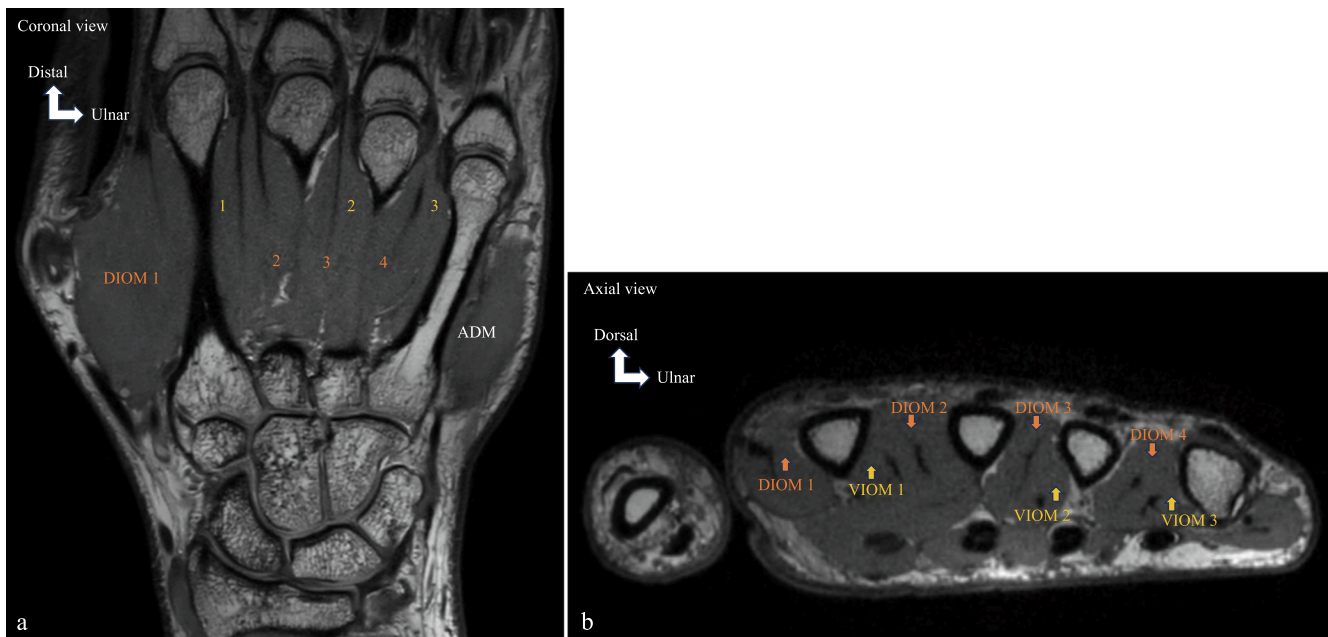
MRI showing the proximal insertions of the dorsal and palmar interosseous muscles. Coronal (a) and axial (b) proton density (PD) MRI sequences. Dorsal interosseous muscles are shown in dark red; palmar interosseous muscles in light orange. VIOM 1, First ventral interosseous muscle; VIOM 2, Second ventral interosseous muscle; VIOM 3, Third ventral interosseous muscle; DIOM 1, First dorsal interosseous muscle; DIOM 2, Second dorsal interosseous muscle; DIOM 3, Third dorsal interosseous muscle; DIOM 4, Fourth dorsal interosseous muscle; ADM, Abductor digiti minimi.
